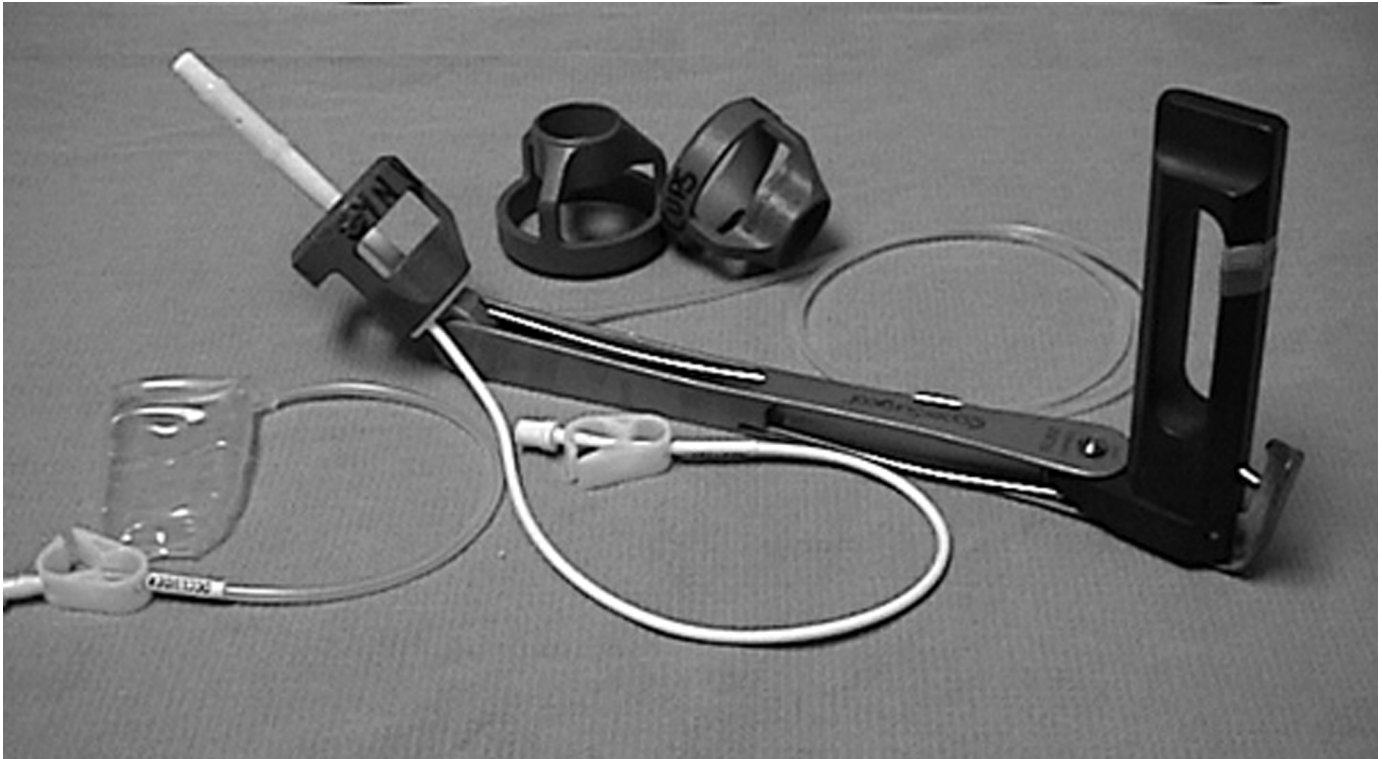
RUMI uterine manipulator is used to manipulate the uterus during surgery, and the Koh colpotomy ring is used to provide an insulated backstop for the colpotomy incision. The vaginal pneumo-occluder balloon maintains the pneumoperitoneum once the colpotomy incision is made. (Cooper Surgical Inc., Trumbull, CT)
